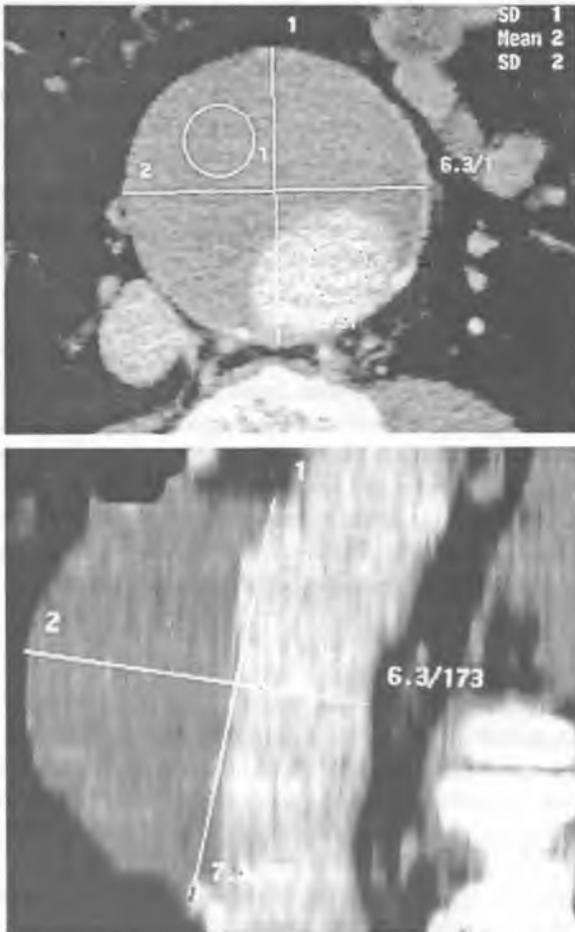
Abdominal aortic aneurysm on axial CT section, with large thrombus inside (A). MPR reconstruction presents the exact length of both aneurysm and thrombus (B)
